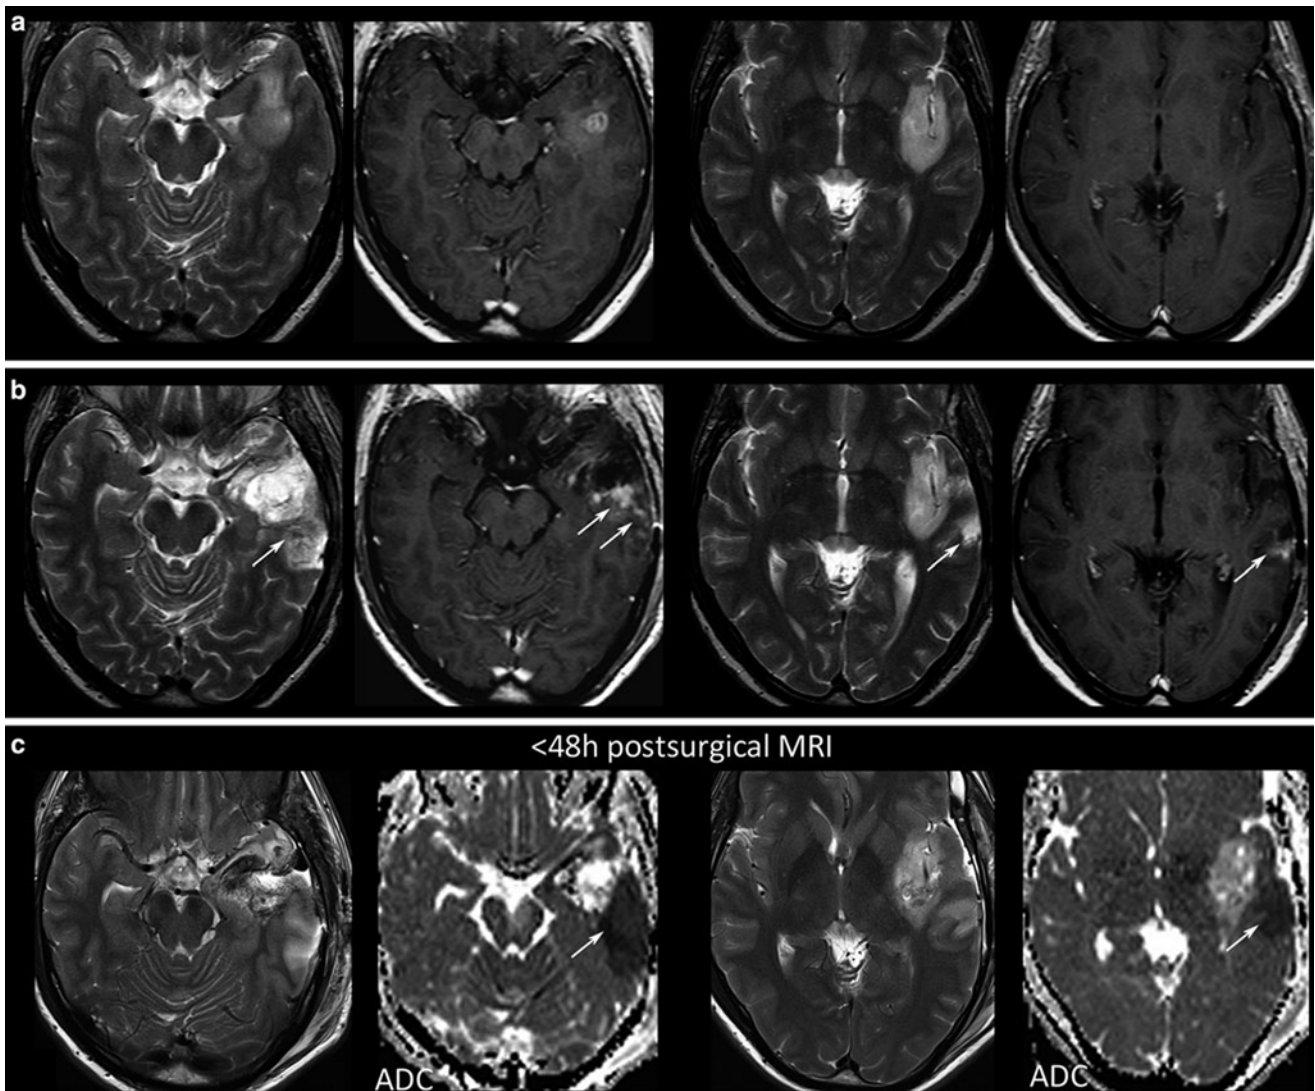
Postsurgical monitoring of a patient with a high-grade glioma: The contrast-enhancing part of the tumor in the temporal white matter (a) was removed, while the insular part was left in place. The MRI control after 3 months showed T2-signal alterations and contrast enhancement in the dorsal margin of the tumor and also in the temporal
